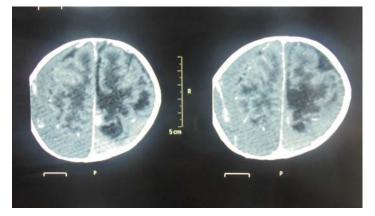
CT Brain (Plain) showing bilateral acute on chronic subdural haemorrhage with maximum thickness of 8mm and 4 mm on left and right side respectively.
